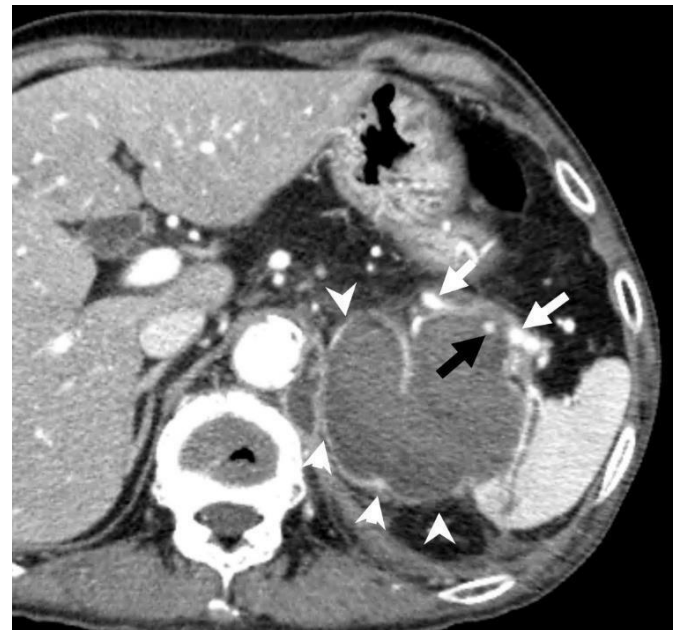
(A). Contrast-enhanced CT demonstrated pseudocyst (arrowheads) with enhancing wall arising from the tail of the pancreas with a small irregular wall enhancing focus (black arrow), probably arising from the splenic artery (white arrows).
